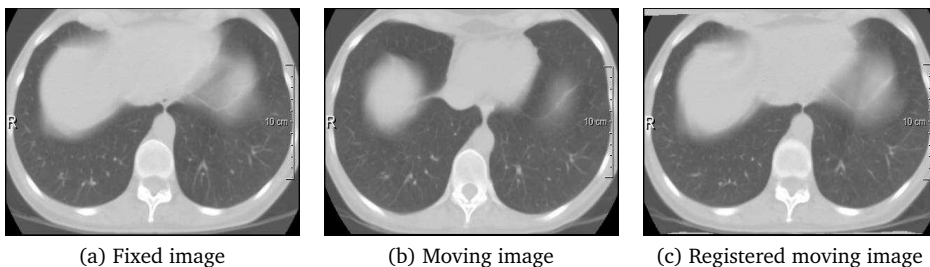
Example of deformable image registration on lung CT images.
